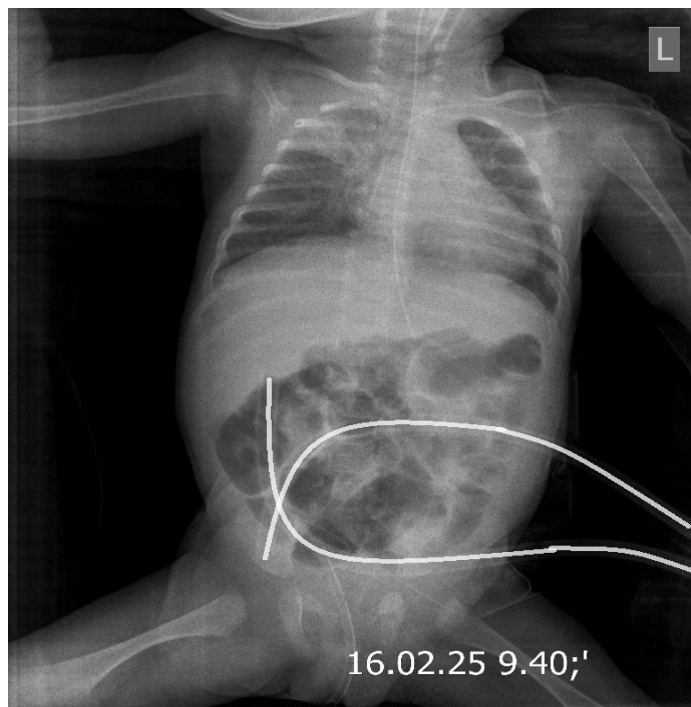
X-ray of child F. After implantation of peritoneal drains (highlighted by white lines)
